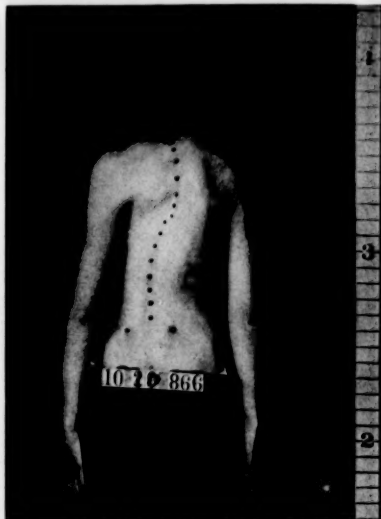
(See x-ray No. 13.)
